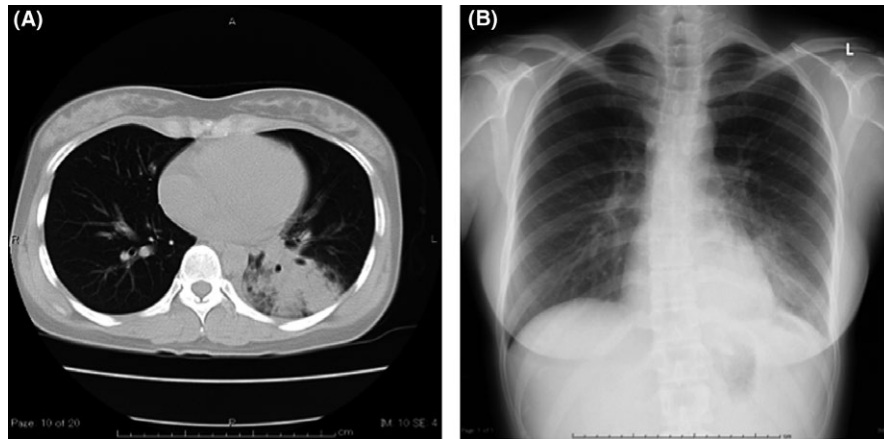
A, Computed tomography on the day of admission shows consolidation with air bronchogram. B, Chest radiograph on the day of admission shows left lower lobe consolidation without silhouette sign
